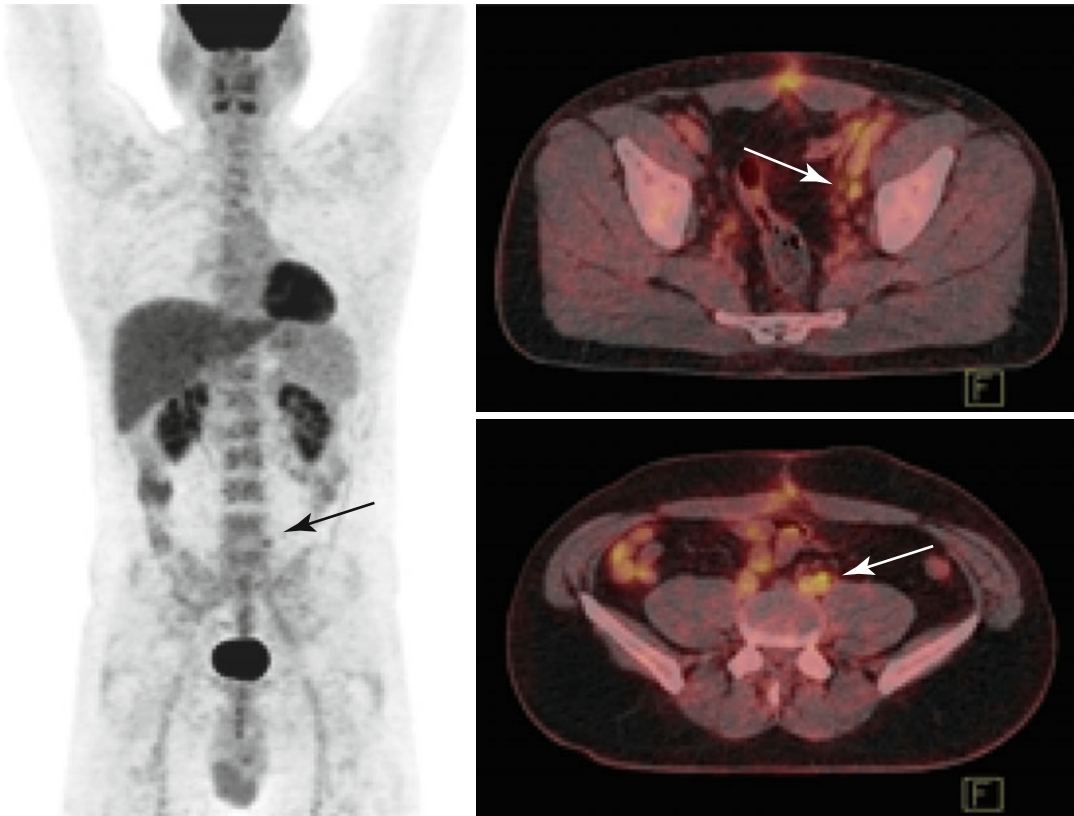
Initial staging PET/CT: hypermetabolic left common (SUVmax 3.1) and external iliac (SUVmax 2.4) lymph nodes – no other evidence of active disease was observed
